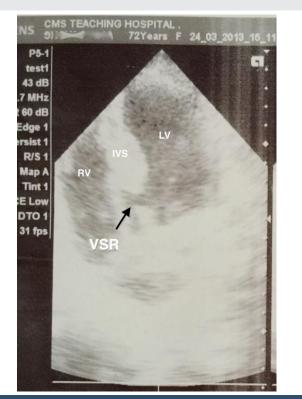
Transthoracic echocardiography in four-chamber view showing a defect in basal ventricular septum (arrow).
